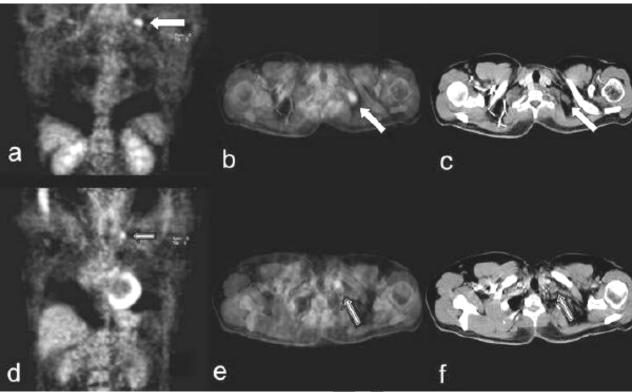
Focal tracer uptakes in the left retroclavicular region (a: coronal and b: transversal) corresponding to a 2.7×1.7 cm lymph node in CT (c) and in the infrajugular region (d: coronal and e: transversal), projecting on a 1.3×1.3 cm lymph node in CT (f). The latter remained unsuspected in the previous MRI investigation.
